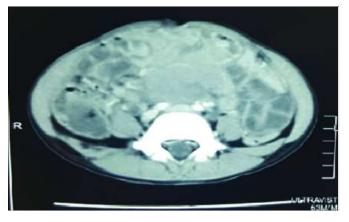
Typical CT scan findings in abdominal Burkitt's lymphoma.
